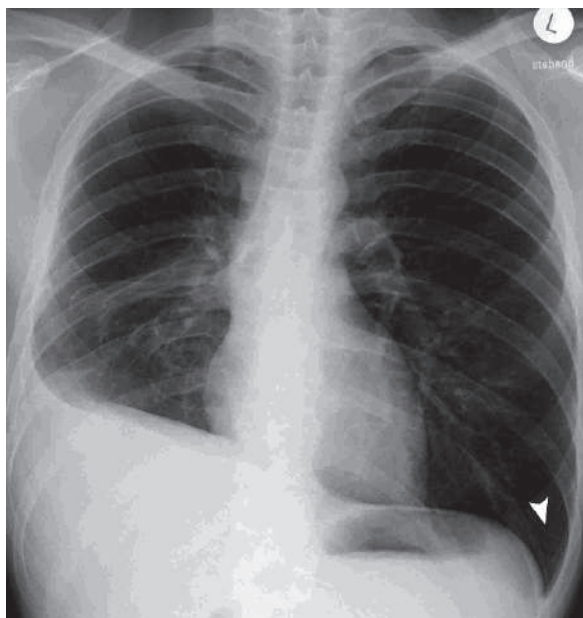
Posteroanterior plain chest radiograph of a patient with postpneumonectomy of the right lower lung lobe shows compensatory emphysema of the left lung with deep sulcus sign (*arrowhead*)
